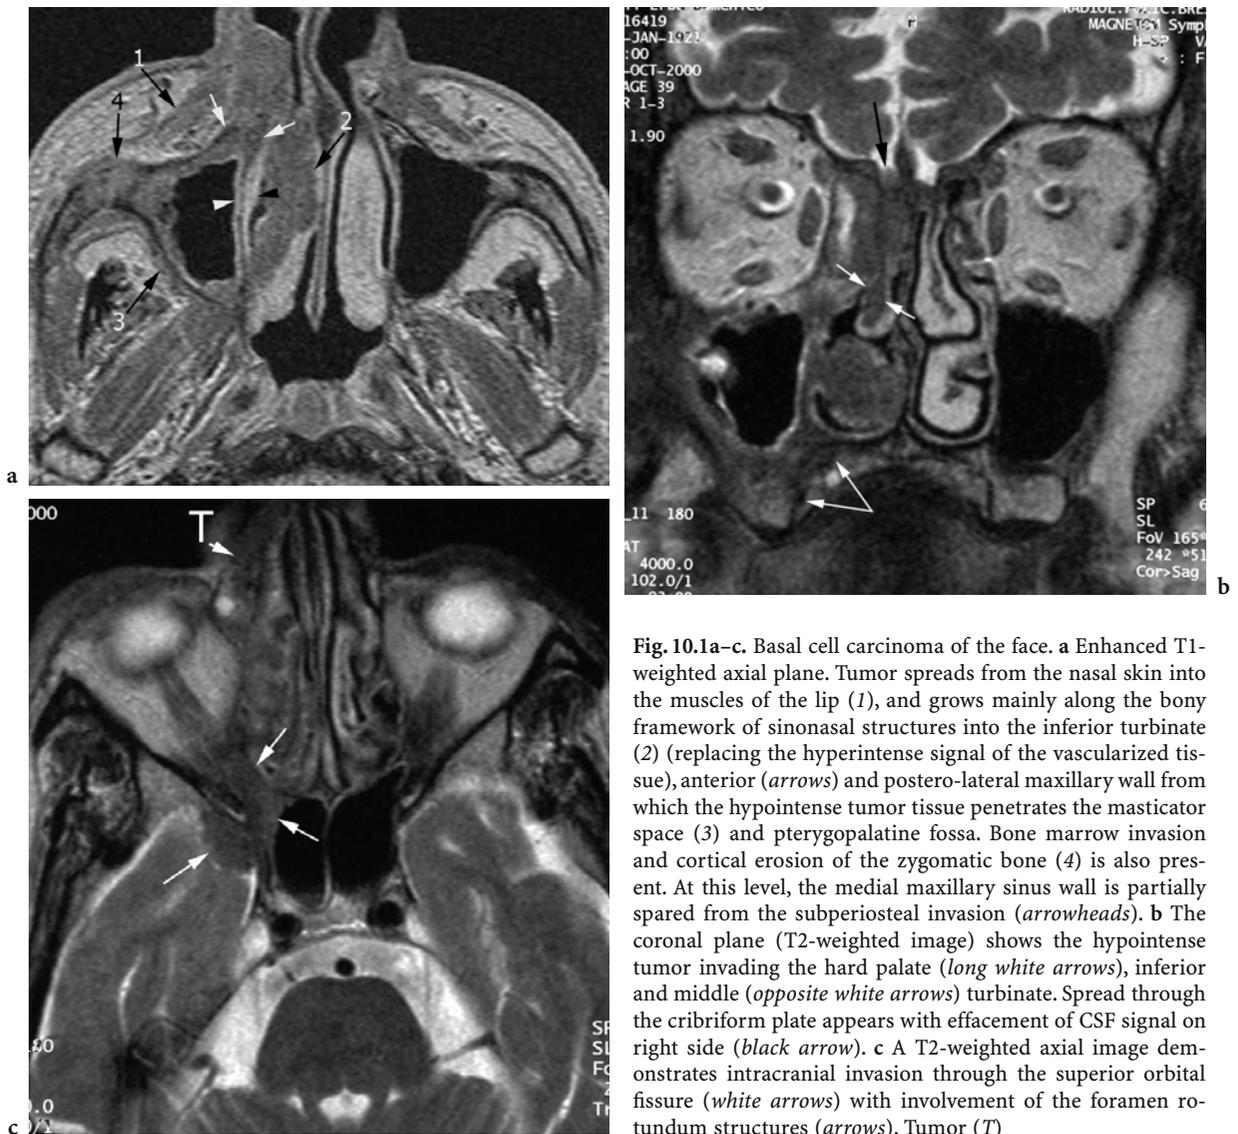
Basal cell carcinoma of the face. a Enhanced T1-weighted axial plane. Tumor spreads from the nasal skin into the muscles of the lip (1), and grows mainly along the bony framework of sinonasal structures into the inferior turbinate (2) (replacing the hyperintense signal of the vascularized tissue), anterior (arrows) and postero-lateral maxillary wall from which the hypointense tumor tissue penetrates the masticator space (3) and pterygopalatine fossa. Bone marrow invasion and cortical erosion of the zygomatic bone (4) is also present. At this level, the medial maxillary sinus wall is partially spared from the subperiosteal invasion (arrowheads). b The coronal plane (T2-weighted image) shows the hypointense tumor invading the hard palate (long white arrows), inferior and middle (opposite white arrows) turbinate. Spread through the cribriform plate appears with effacement of CSF signal on right side (black arrow). c A T2-weighted axial image demonstrates intracranial invasion through the superior orbital fissure (white arrows) with involvement of the foramen rotundum structures (arrows). Tumor (T)
